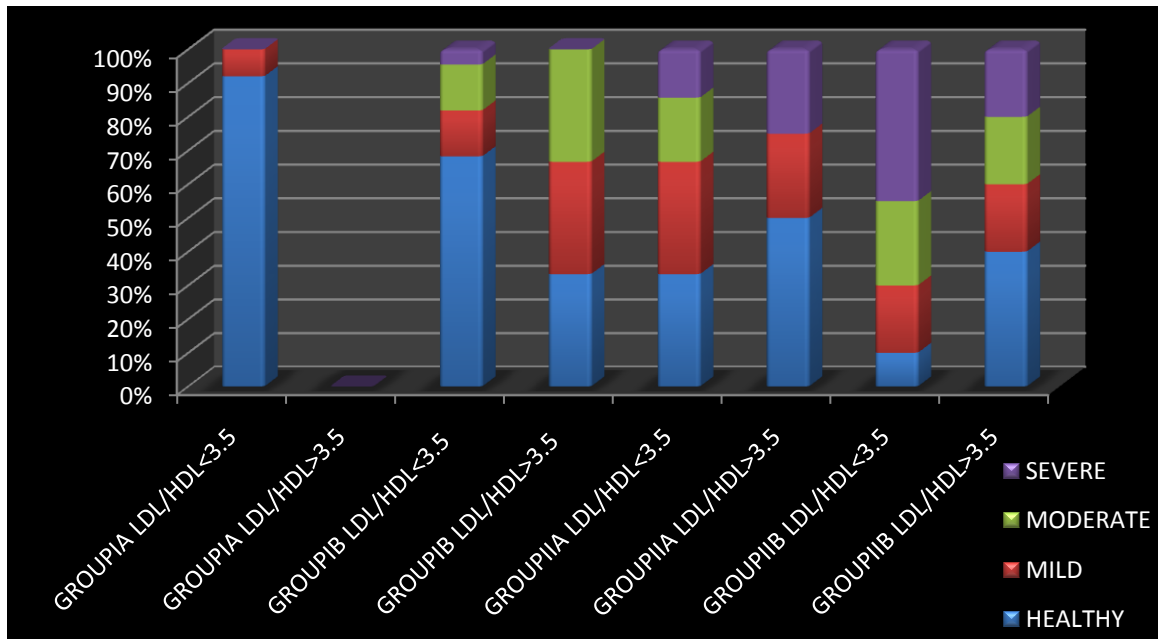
PREVALENCE OF PERIODONTITIS WITH RESPECT TO HDL:
